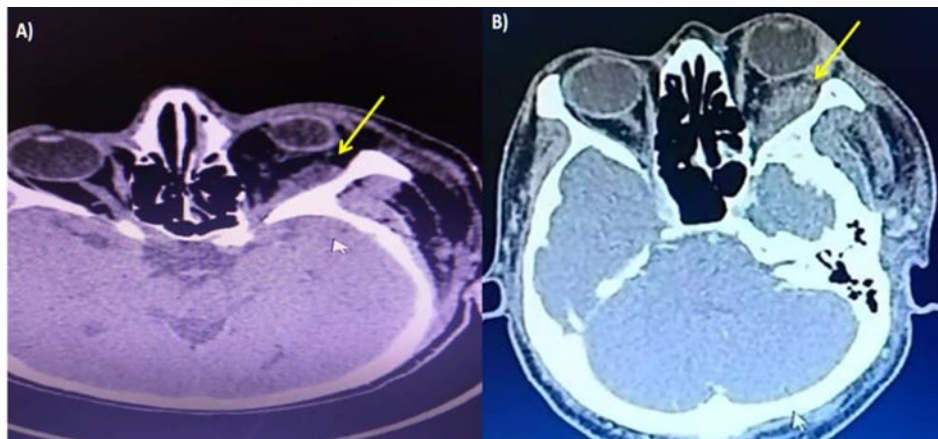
A. MRI shows extraconal enhanced soft tissue mass (white arrow) B. Repeat MRI 5 days later shows more extraconal enhanced tissue mass causing obvious proptosis (white arrow)
